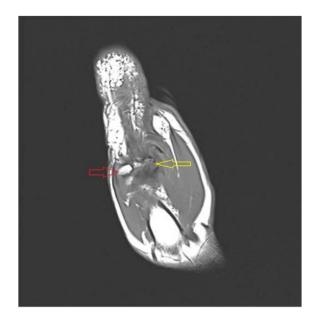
Coronal, T1 weighted MRI best demonstrates the fractured ulnar sesamoid bone (yellow arrow). Radial sesamoid is identified and intact for reference (red arrow).
